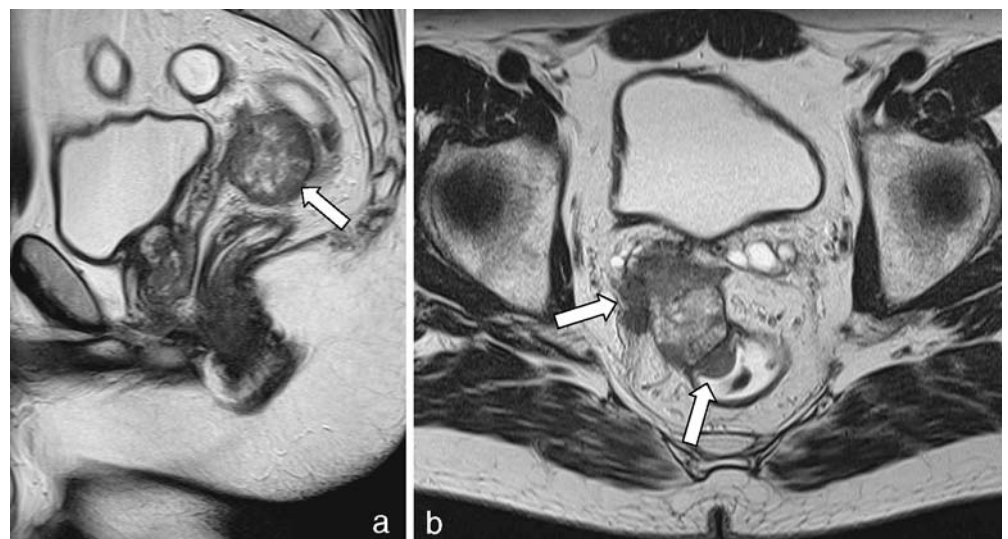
Example of an extraluminal recurrence involving the vagina. a Hypointense presacral scar with a small seroma is seen on sagittal T2-weighted TSE image. Also, tumor inside the vagina can
